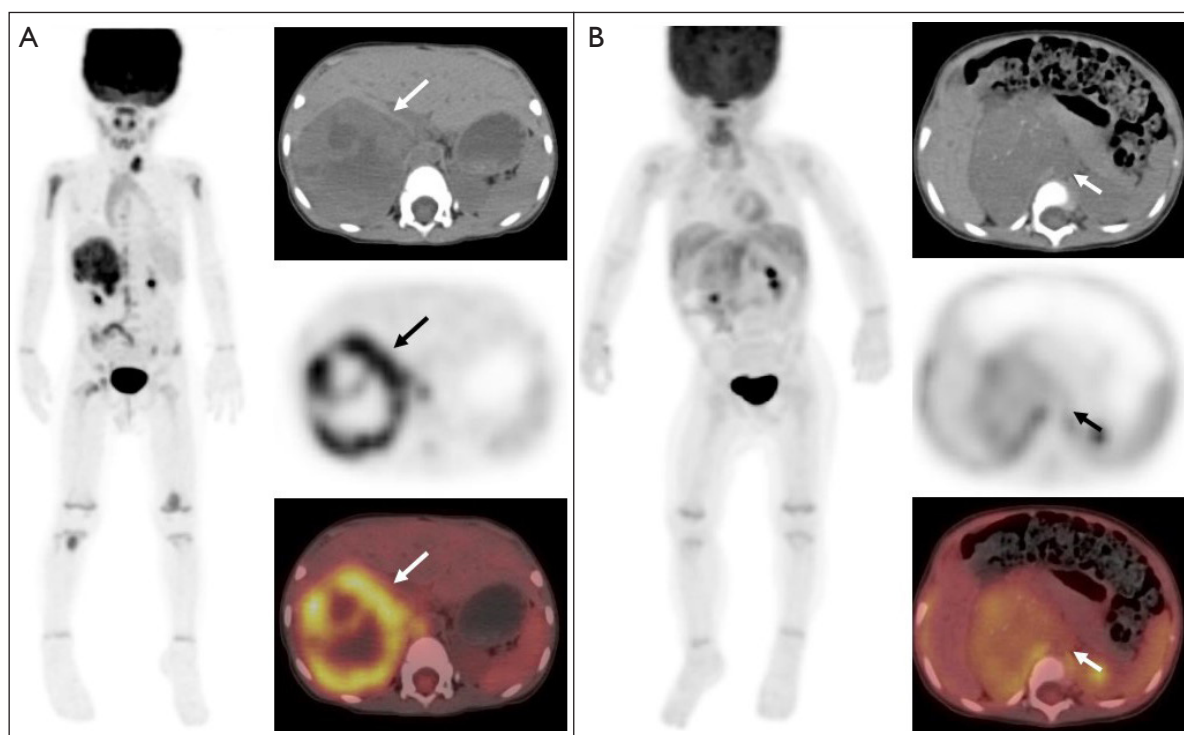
2-[^{18}F]FDG PET/CT of pediatric patients diagnosed with high- and low-risk neuroblastoma by the combined diagnostic model. (A) A 2-year-old boy was diagnosed with high-risk neuroblastoma characterized by *MYCN* amplification and multiple bone metastases [the arrows in (A) indicate the main lesion]. Despite undergoing surgery chemotherapy and immunotherapy, the disease still progressed and ultimately resulting in death. (B) A 1-year-old girl was diagnosed with low-risk neuroblastoma by the combined diagnostic model [the arrows in (B) indicate the main lesion]. The girl achieved complete remission following surgical intervention and chemotherapy, with no evidence of recurrence during the 30-month follow-up period. 2-[^{18}F]FDG PET/CT, 2-[^{18}F]fluoro-D-glucose positron emission tomography/computed tomography.
